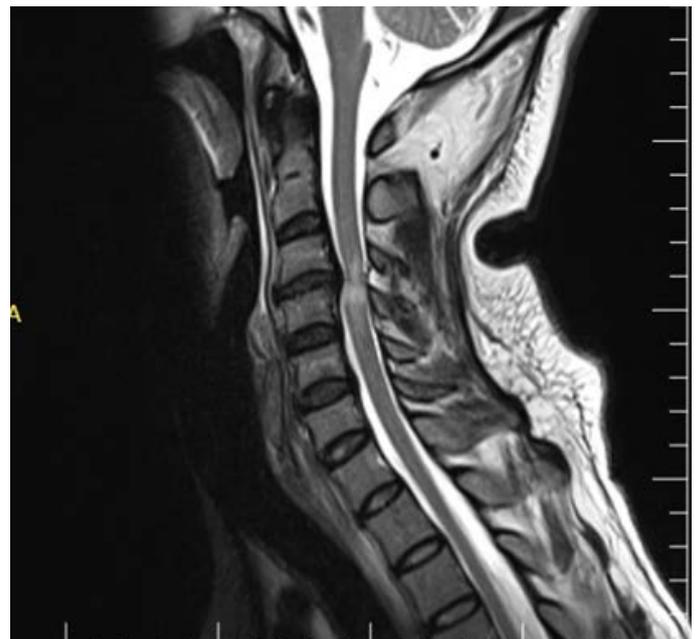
Cervical MRI: Posterior central protrusion disc herniation in the C3-4 disc. C3-4 vertebral corpus corners showed osteophytic tapering.
